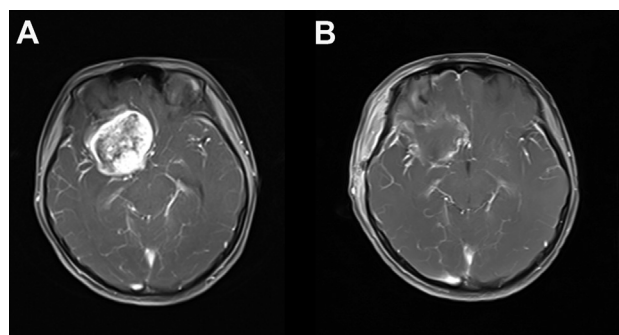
Magnetic resonance imaging exhibiting surgical treatment. (A) Preoperative T1-enhanced image of a patient shows that the tumor was characterized by heterogeneous enhancement. (B) Postoperative T1-enhanced image shows that gross total resection was achieved.
